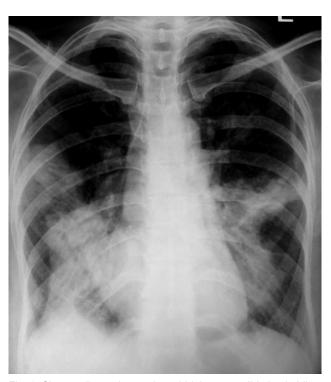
Chest radiograph reveals multi-lobar consolidation in bilateral lower lobes and the right mid-zone, which are sharply demarcated.
